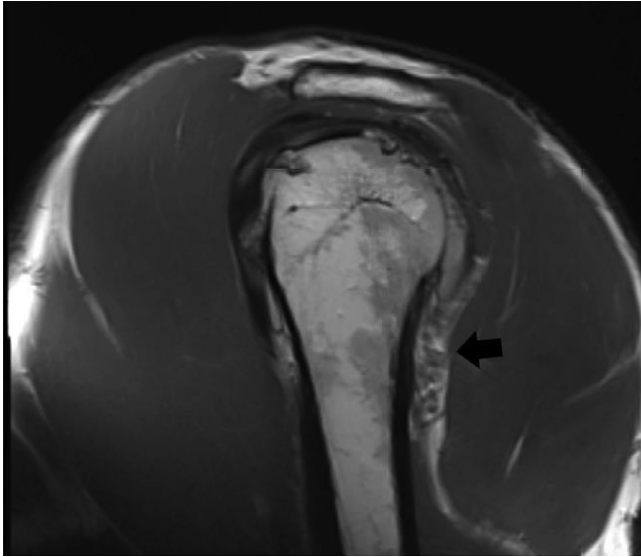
Sagittal T1 MRI of the left shoulder at the level of the proximal humerus demonstrates isolated atrophy of the teres minor muscle (black arrow) in relation to the other rotator cuff muscles.
